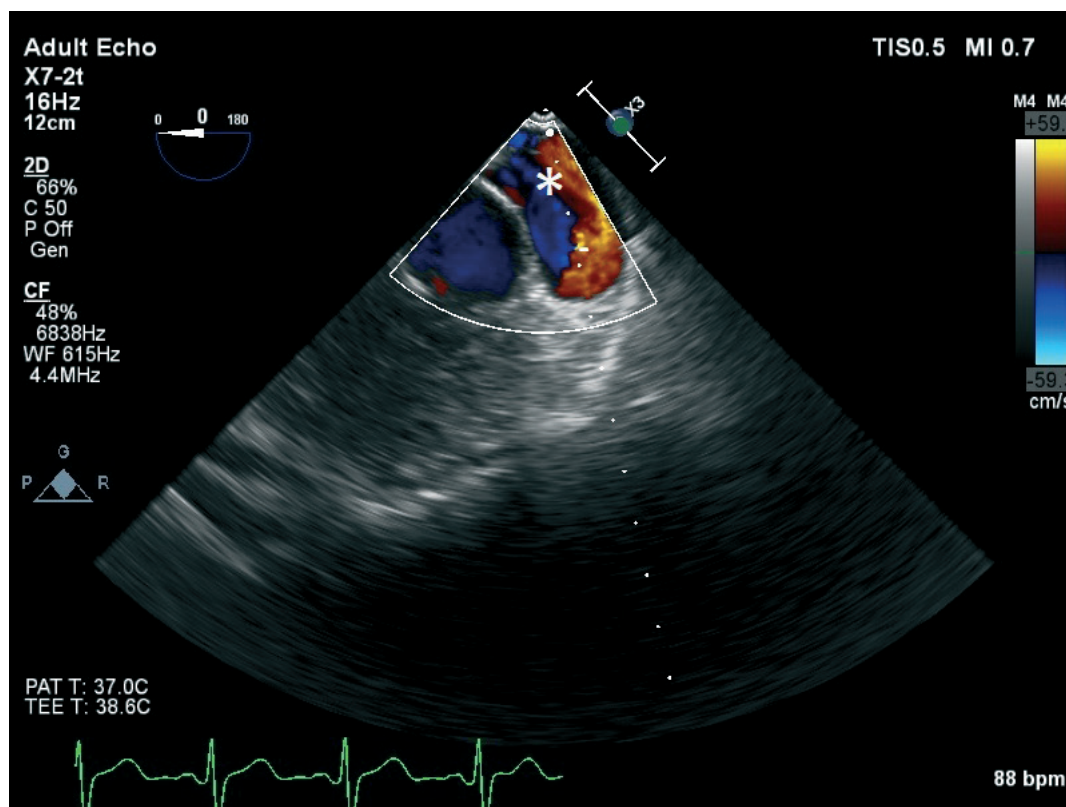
Transesophageal echocardiography: lower esophageal view showing blood flow in a dilated coronary sinus (asterisk)
